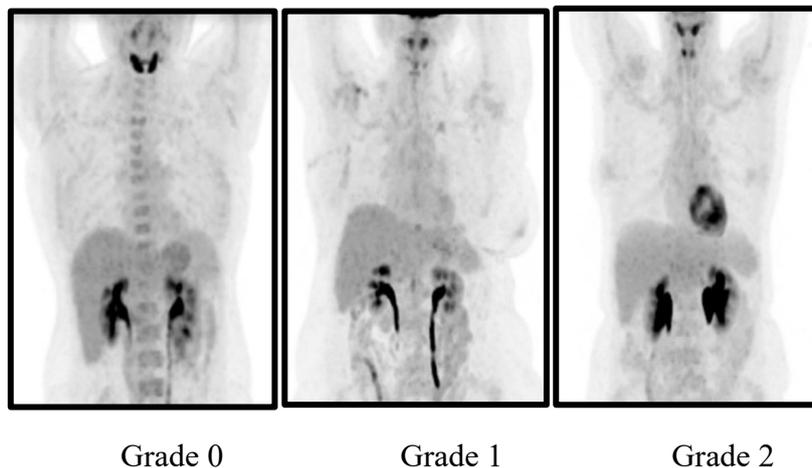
Variable grades of myocardial FDG uptake on maximum intensity projection reconstruction.
